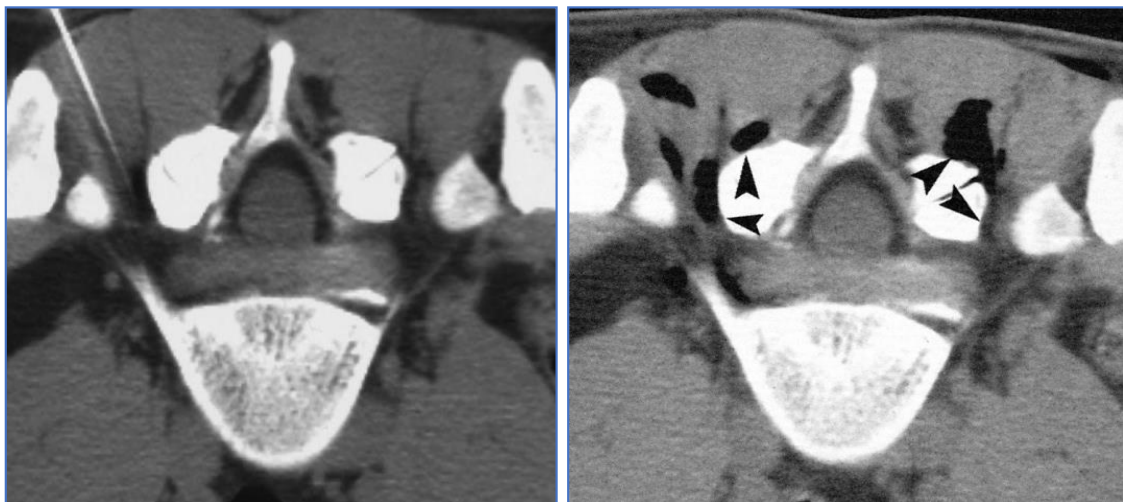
Intraprocedural spinal CT scan. *A*): Correct positioning of the needle in the periganglionic region; *B*): CT-guided control of the oxygen-ozone gas mixture injected into the foraminal region and facet joints (arrowheads).
